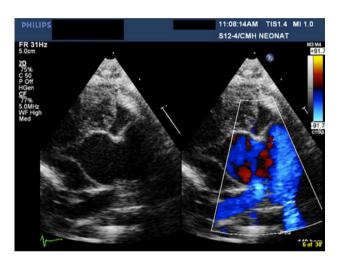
Parasternal short-axis 2D and color Doppler echocardiogram demonstrating the APW
